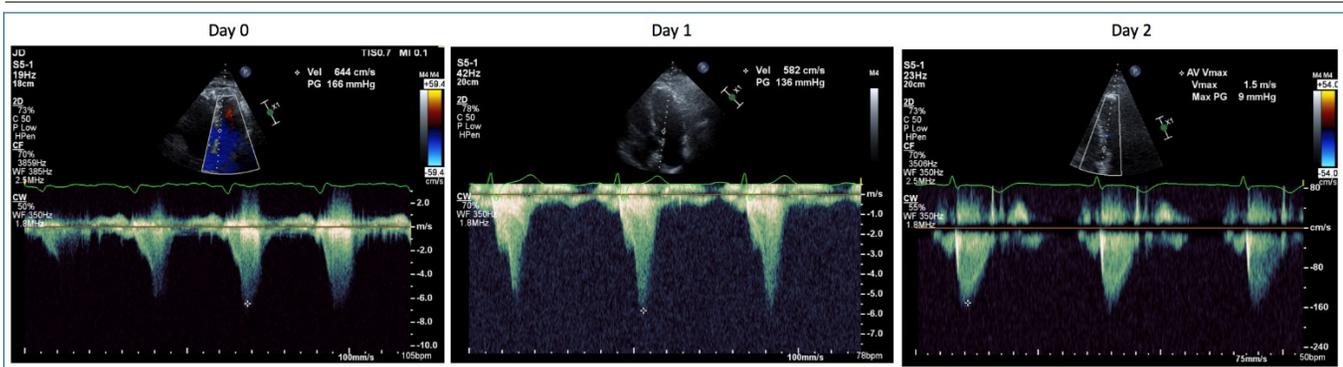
Serial TTE Images Using Continuous Wave Doppler Ultrasound to Assess the Aortic Valve Peak Gradient Which Showed Reducing LVOT Obstruction from Day 0 to Day 2.
